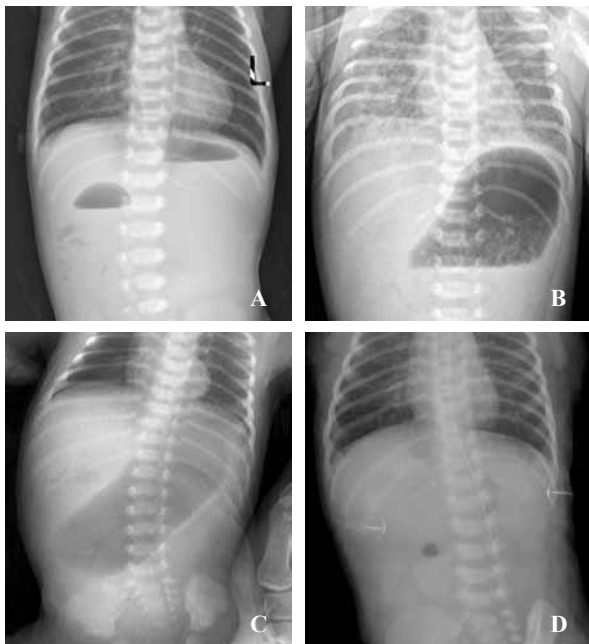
Various appearance of duodenal obstruction under upright abdominal radiograph. A: Classic "double bubble sign" with less gas distributed in the distal intestine; B: Markedly dilated stomach fill with air and fluid displayed a "single bubble sign" in the upper abdomen; C: Massively dilated stomach without evidence of distal intestinal air; D: Uneven gas distribution. Intestinal gas mainly located in the left upper quadrant, and the rectal gas was found.
